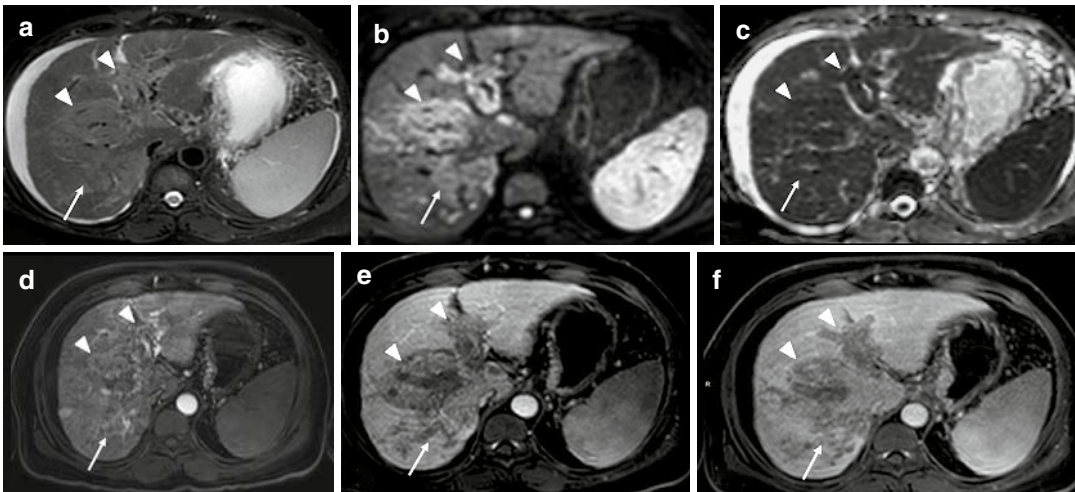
A 43-year-old male with an infiltrative type of hepatocellular carcinoma. (a) Axial T2-weighted MRI showed an ill-defined hyperintense area in the right lobe of the liver (arrow) with extension along the portal vein (arrowheads). There is a nodular outline of the liver and mild perihepatic free fluid. (b, c) Axial high b-value (b=800) DWI (b) and ADC images (c) showed diffusion restriction in the lesion (arrow) and within the portal vein
